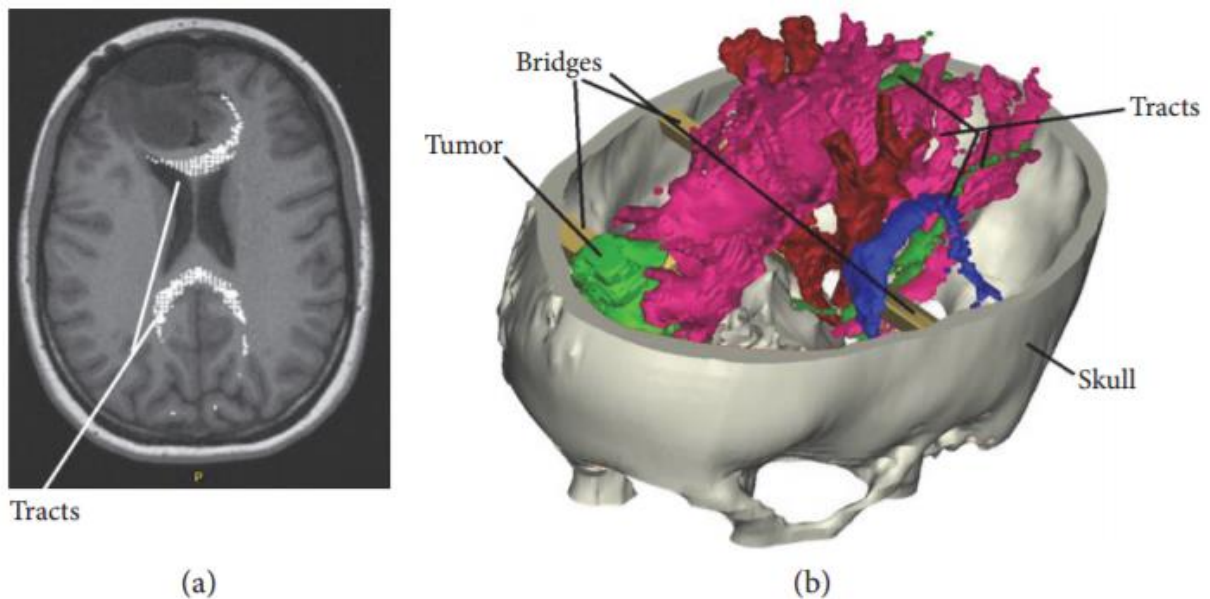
TRACTS superimposed on MRI structural data. (a) 3D model including skull from CT, tumor from MRI, fiber tracts, and connecting bridges (b).
